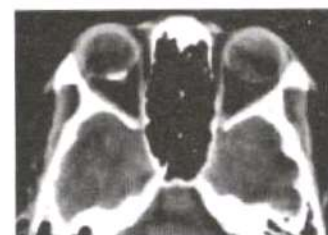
CT scan showed a radio opaque plaque of bone density at the level of posterior pole in OD
